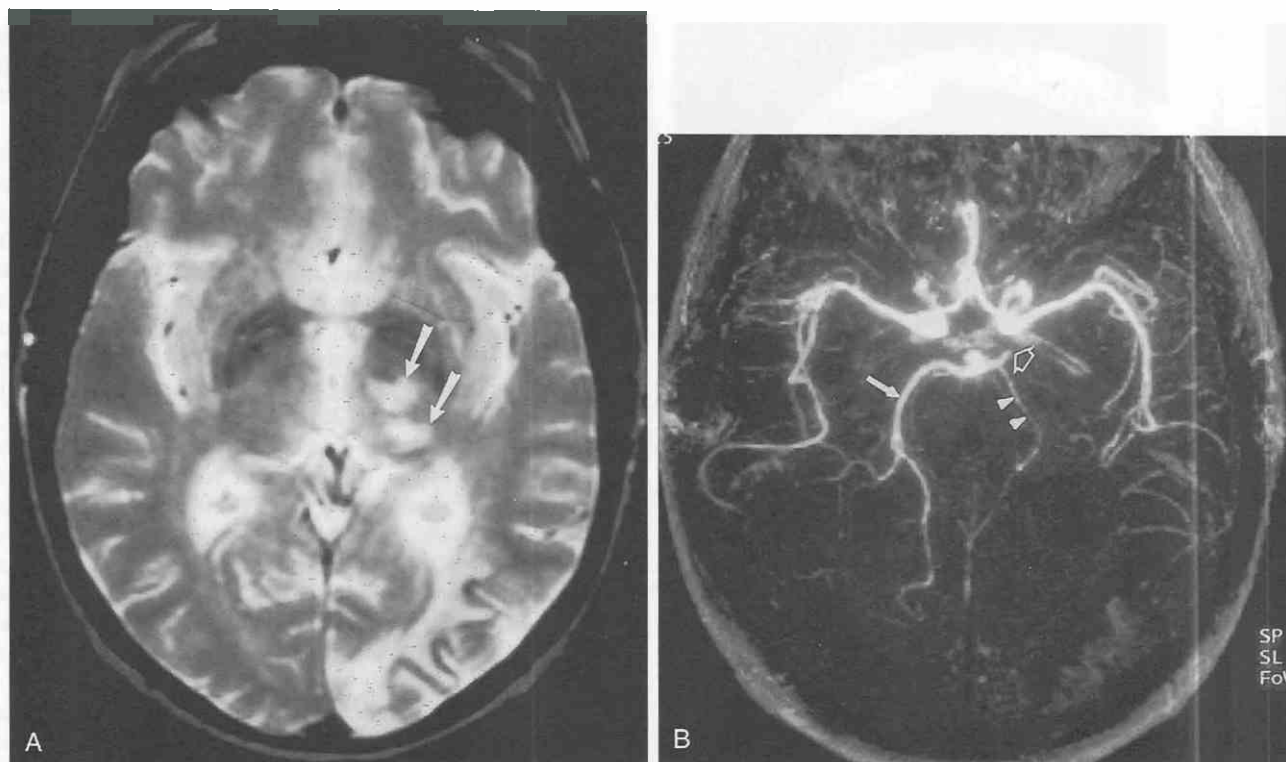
Left posterior cerebral artery (PCA) stroke. *A*, T2-weighted axial image shows increased signal in the left occipital lobe. Focal areas of increased signal are also seen in the left thalamus (arrows). Infarction of the thalamus may accompany PCA stroke as a result of occlusion of thalamoperforate arteries originating from the proximal PCA. *B*, Maximum intensity projection image (viewed from beneath) from 3D time-of-flight MRA. The left PCA is occluded proximally (open arrow). The right PCA has a normal appearance (arrow). The left superior cerebellar artery is visible (arrowheads).
